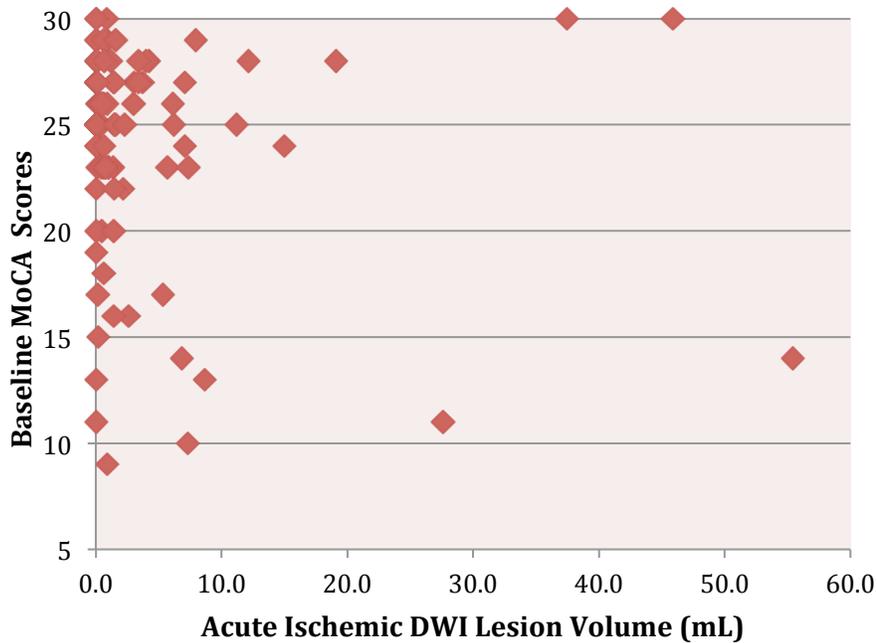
Acute ischemic DWI lesion volume demonstrates no significant relationship to patient MoCA scores at baseline. DWI indicates diffusion-weighted imaging; MoCA, Montreal Cognitive Assessment.
